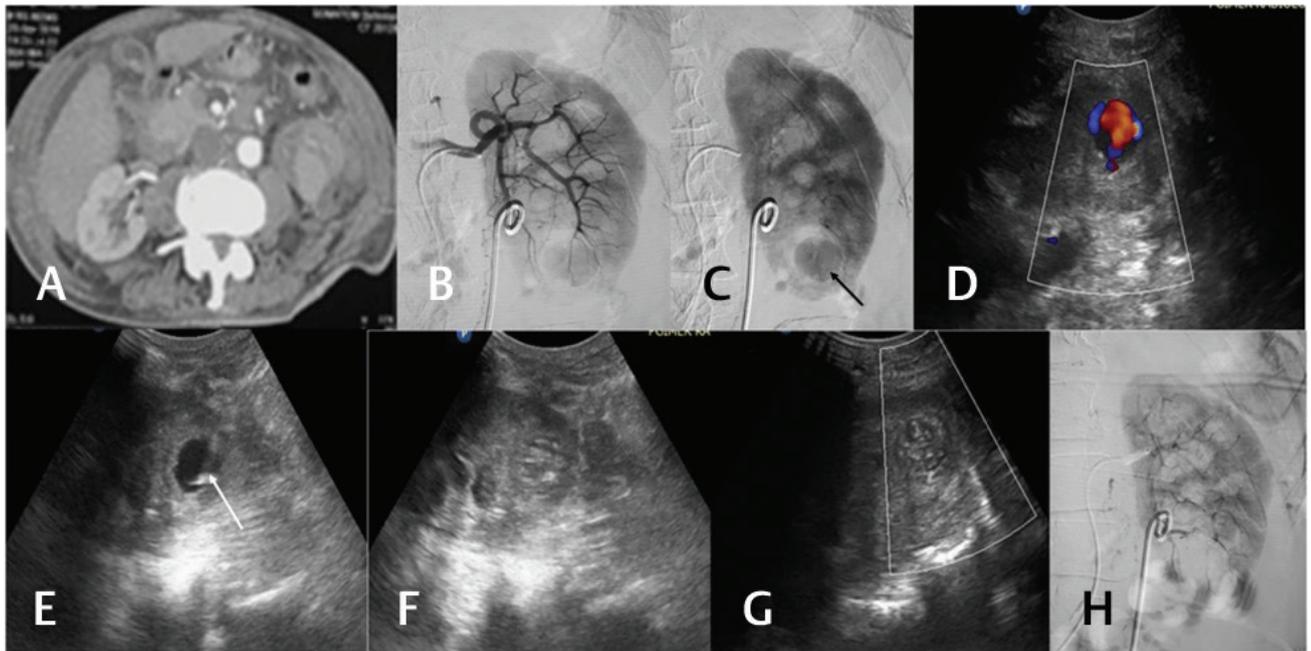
(A) Left renal pseudoaneurysm post percutaneous nephrolithotomy. (B,C) DSA images showing the pseudoaneurysm in the lower pole (black arrow) with DJ stent in situ, the parent artery could not be selectively cannulated. (D) Color Doppler ultrasonography (USG) showing yin-yang pattern of color flow within the pseudoaneurysm. (E) Percutaneous placement of 22G spinal needle into the sac of pseudoaneurysm under USG guidance (white arrow). (F) Injection of thrombin into the pseudoaneurysm. (G) Color Doppler post thrombin embolization showing no color flow within the sac. (H) Post embolization DSA showing no opacification of the pseudoaneurysm.
